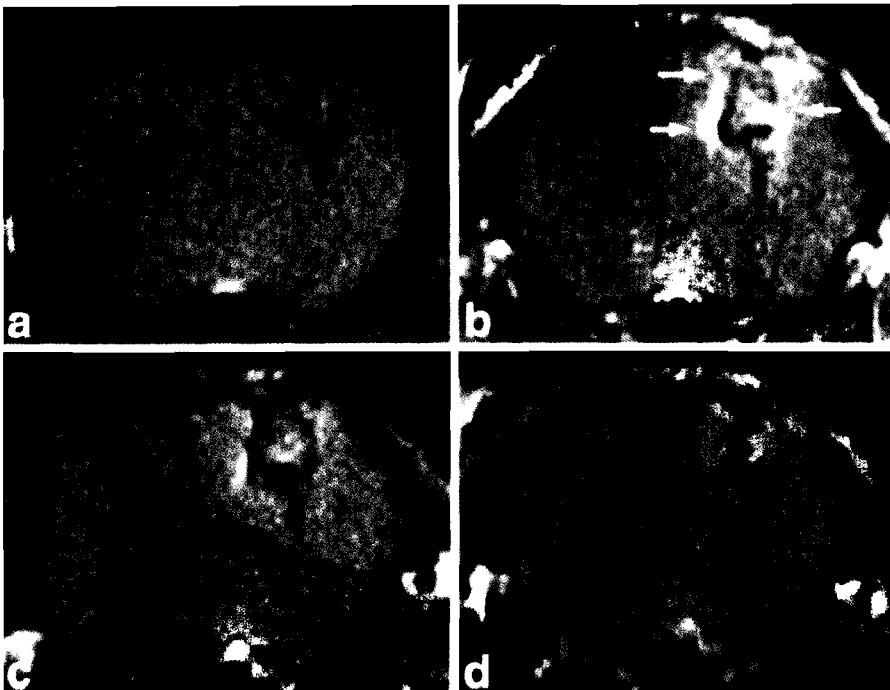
Repetitive contrast enhanced MRI scanning for the evaluation of the post-transplantation status of the BBB (for technical details see Isenmann et al., 1996b). a. T1 weighted image showing tissue graft in the left cortex and striatum 20 days after transplantation. b-d. Contrast enhanced T1 weighted images 20 (b), 36 (c), and 70 days (d) after transplantation. Signal enhancement indicating BBB damage is readily detected 20 days after grafting (b), but decreases markedly within the following weeks (c, d). x 10
